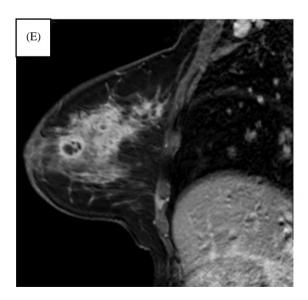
24 years old female right breast enlargement with palpable masses. Conventional MRI (A & B): Asymmetrically enlarged right breast showing hyperintense T2 and STIR masses. Associated diffuse breast edema and skin thickening. DCE-MRI (C, D & E): Increased right side background parenchymal enhancement with regional heterogeneous NME and multiple enhancing foci and rim-enhancing fluid collections. Some are seen intercommunicating with each other.
